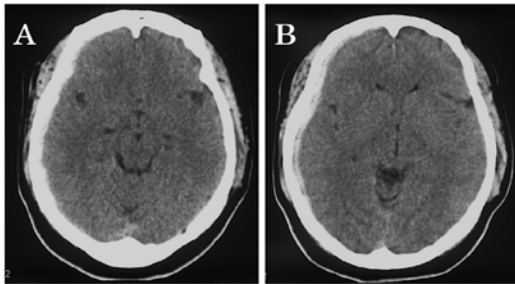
Case 1, an obese 31-year-old woman. Head CT (axial image). CT shows a thin right ASDH.
